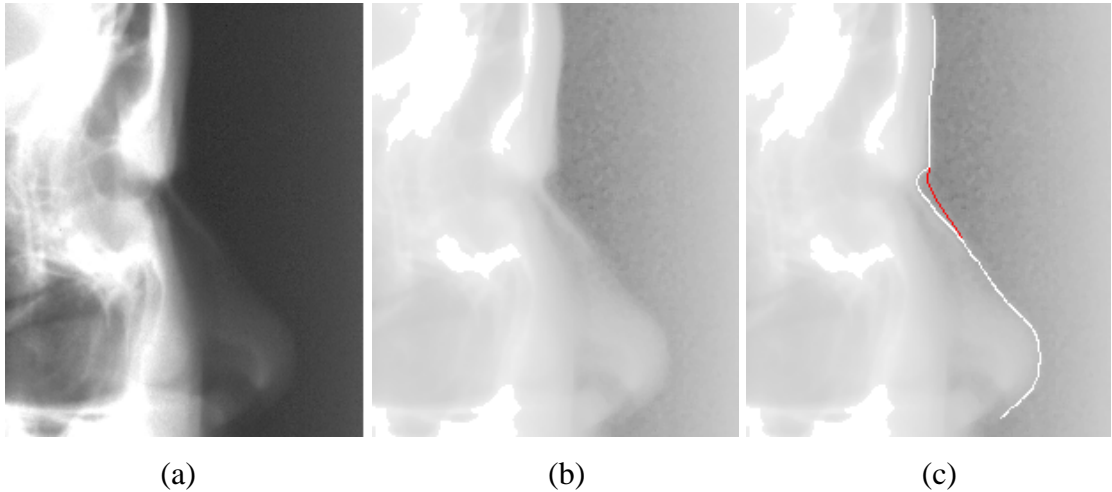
The edge detection near the nasion. (a) The original X-ray. (b) Enhanced soft tissue. (c) Edge detection.
